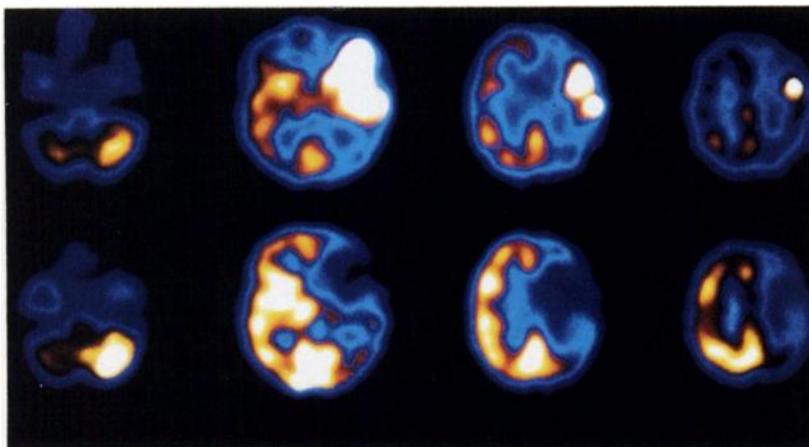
These single-photon emission computed tomography (SPECT) studies of regional cerebral blood flow, obtained with technetium-99m hexamethylpropyleneamine oxime (HM-PAO) in a patient with acute stroke, demonstrate luxury perfusion (upper row, day 13) which subsequently resolves into a large area of ischemia and necrosis (lower row, day 40). (Courtesy of Durval C. Costa, MD, and Peter J. Ell, MD; Middlesex Hospital Medical School, London, England)
